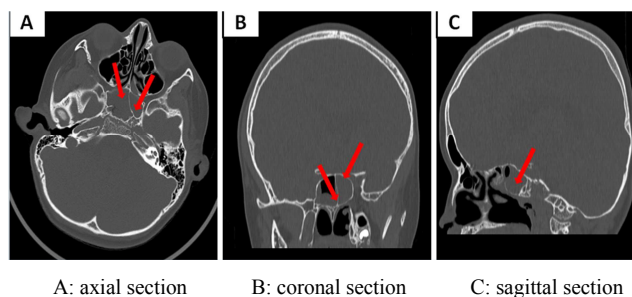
Brain computed tomography demonstrates fluid collection in the sphenoid sinuses.
